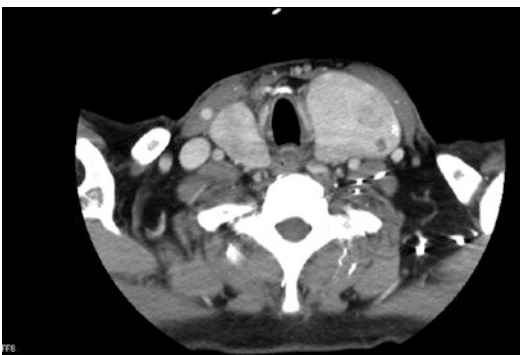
Thoracic CT scan showing high vascularity of retrosternal goiter
